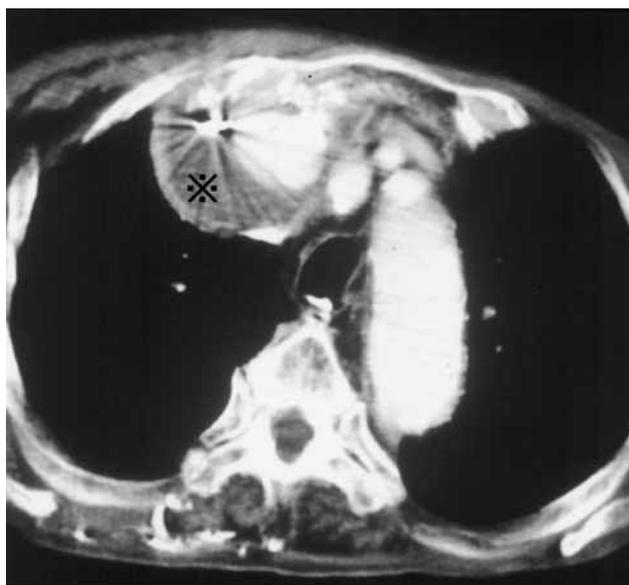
Chest computed tomography revealed pseudo-aneurysm () of the brachiocephalic artery.
